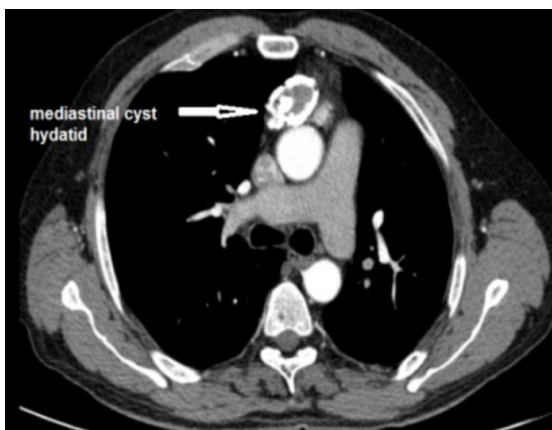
Thoracic Computed Tomography showing the lesion
